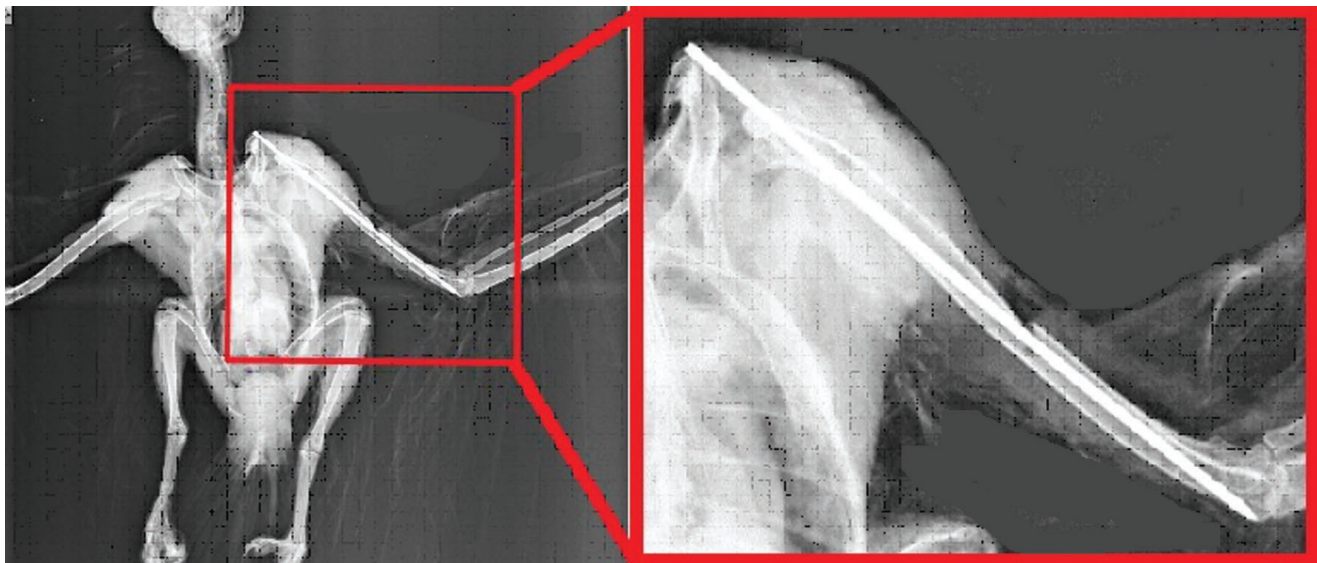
Post-operative radiograph of left wing (humerus).
